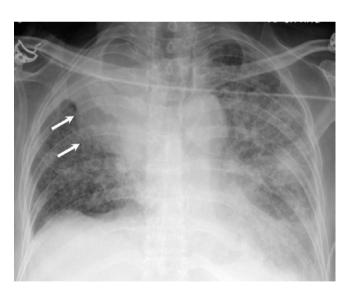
Golden S sign. A 75-year-old man with right hilar mass. Frontal radiograph of the chest shows right upper lobe collapse with bulging of the right minor fissure (arrows)
